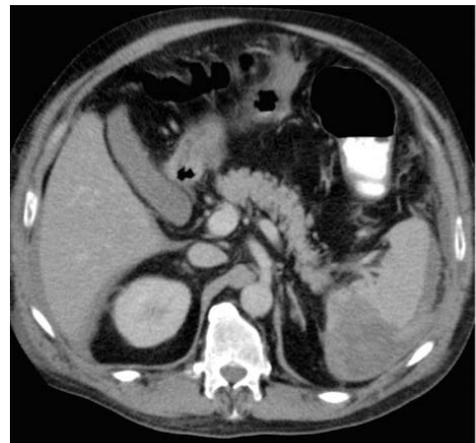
CT scan 4 days following splenic embolization demonstrates resolution of the pseudoaneurysm, and no extravasation, with the resolving contusion and a component of minor splenic infarction in the embolized segment.
